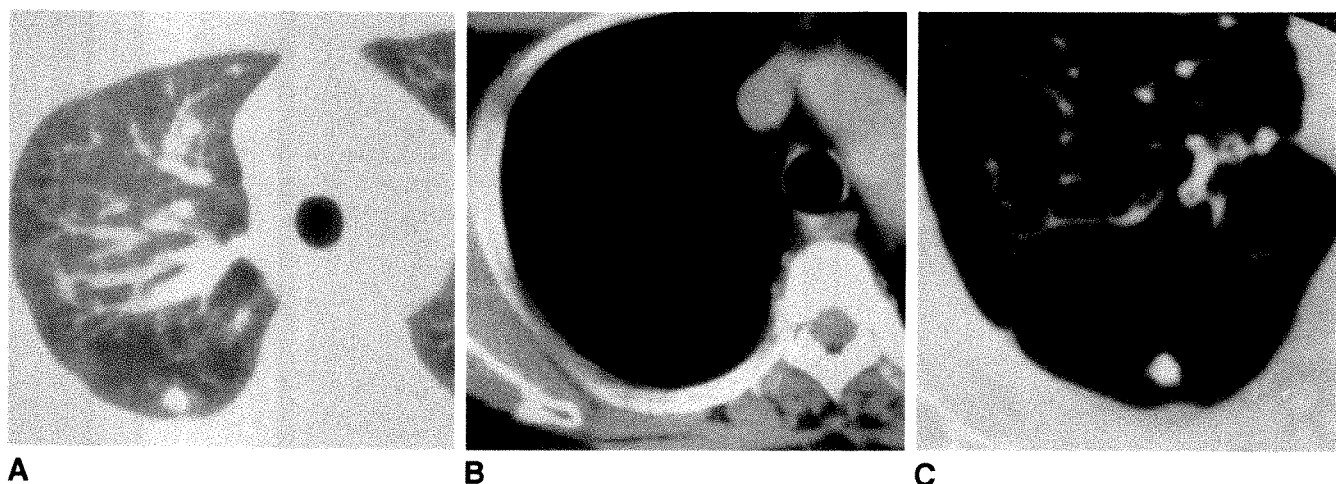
A, Conventional CT scan with 1-cm collimation at level of a nodule in right lung.
